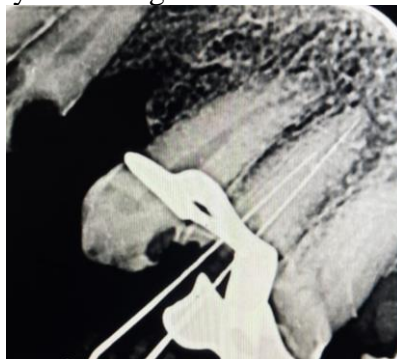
Overview of the Archives on Periapical Radiography
